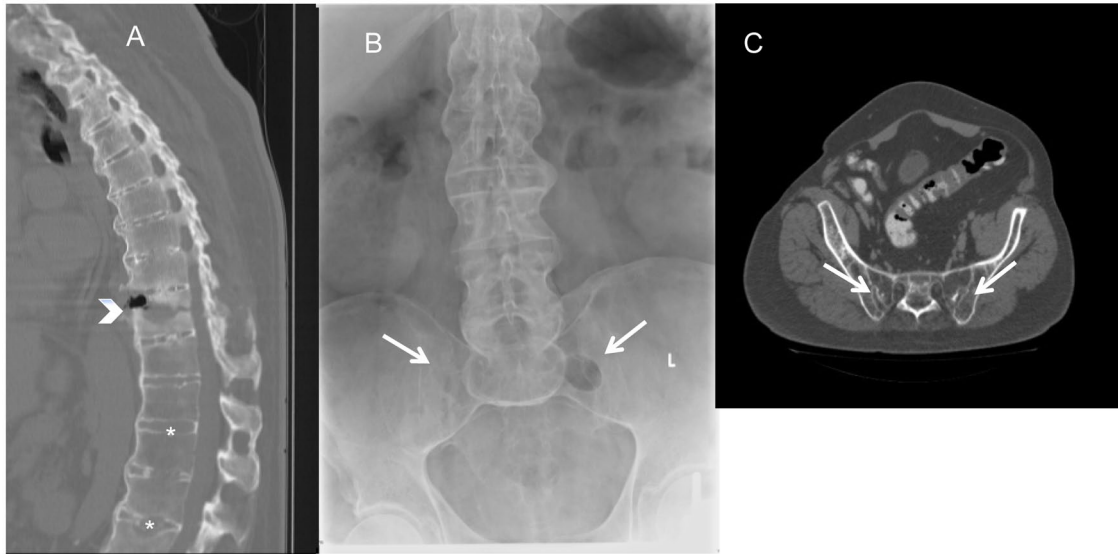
A 50-year-old man presented to the clinic with mid back pain that started three months ago after a fall off a ladder. CT scan midsagittal view (A) of the thoracic spine showing T10 hyperextension fracture nonunion (arrowhead). Plain radiograph anteroposterior view (B) of the lumbar spine showing bamboo spine, fusion of the sacroiliac joints (arrows). Both the CT and the plain radiograph showing preservation of the intervertebral disc space (stars). CT scan axial view (C) of the pelvis showing fusion of the sacroiliac joints (arrows).
